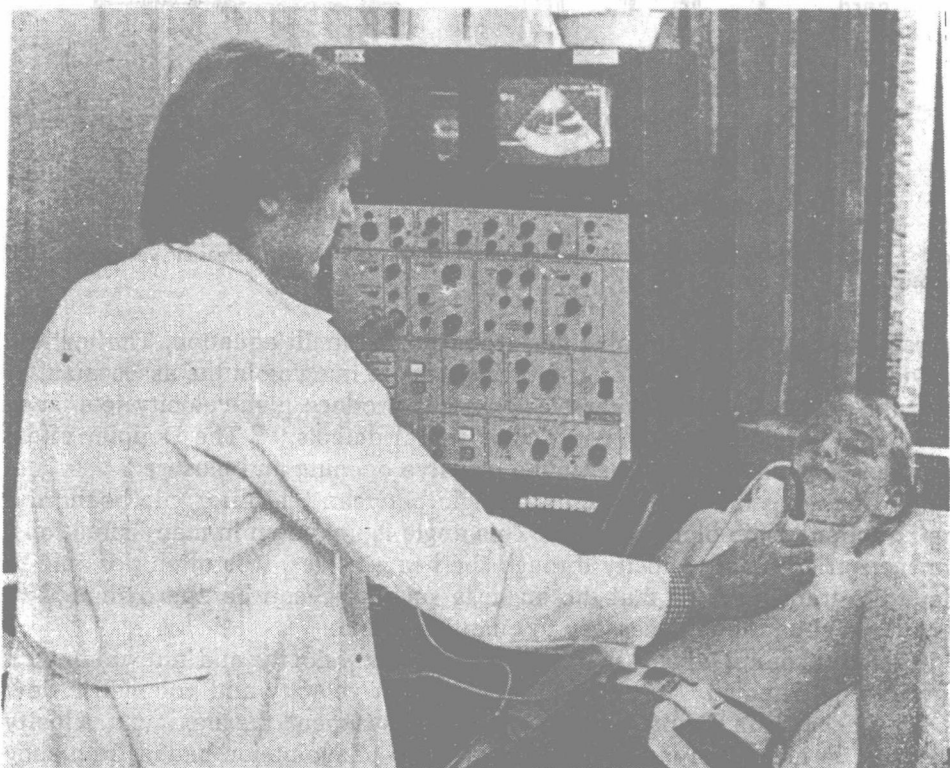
Combined real-time two-dimensional imaging and Doppler instrument (IREX Medical Systems, Ramsey, NJ).
